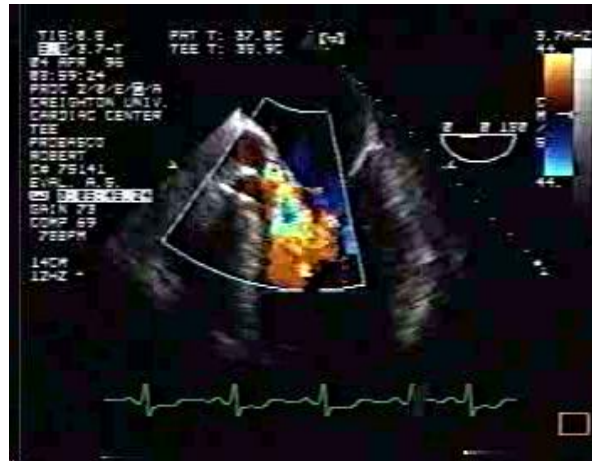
Echocardiogram in Aortic Regurgitation
